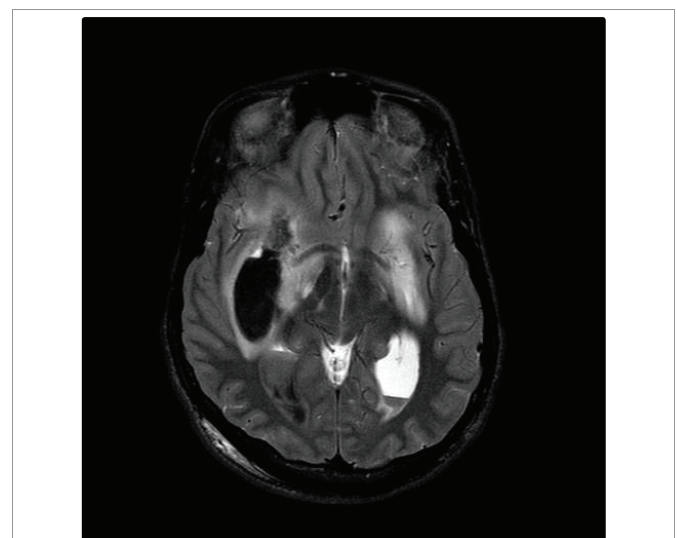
MRI brain on day 3 axial T2 showing bilateral lateral ventricular hemorrhage with fluid-fluid level..
